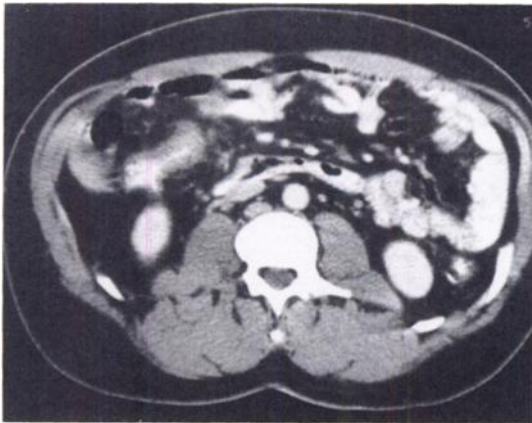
An abdominal CT scan demonstrates a single loop of thickened bowel in the right mid abdomen.
